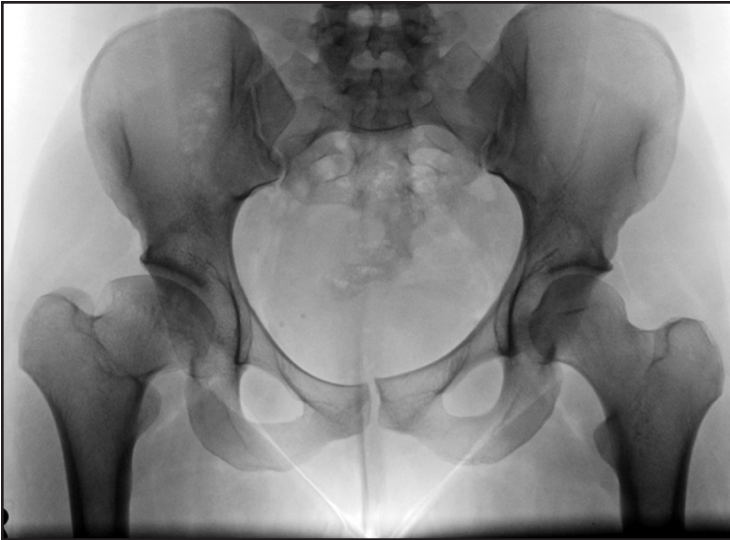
Preoperative radiograph of a 22-year-old woman with a dysplastic right hip and Perthes-like deformity of her right hip.
